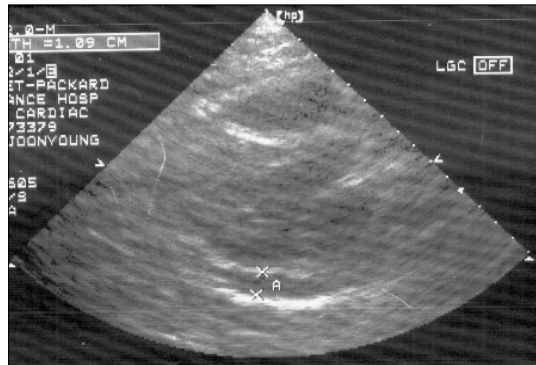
Parasternal long axis view of echocardiography at admission shows pericardial effusion about 1.09 cm.
